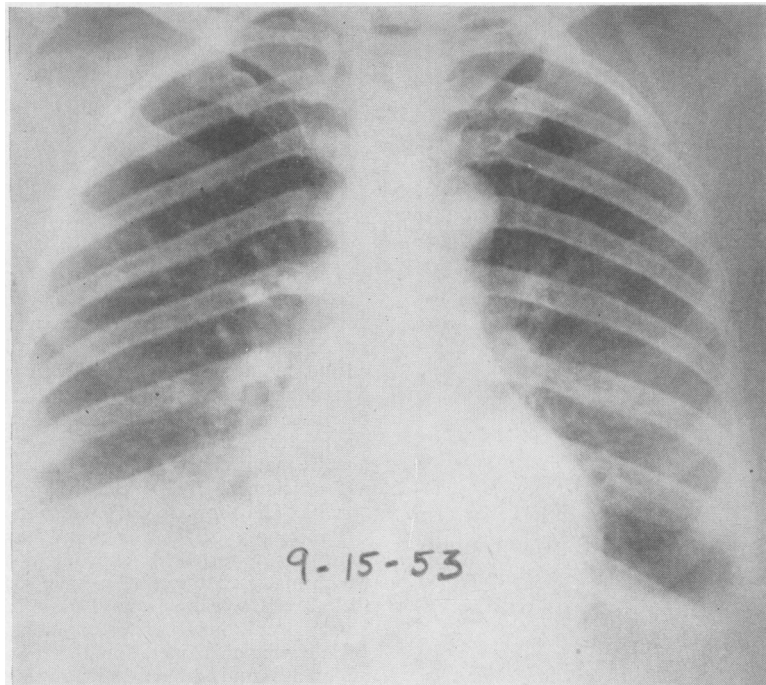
Case 2. Radiograph several days after venous thrombotic obstruction to lymph drainage. Bilateral pleural effusions and a fine diffuse pulmonary infiltration are present.
